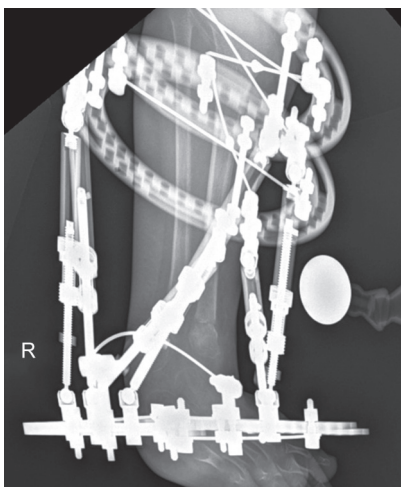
Antero-posterior radiograph showing initial correction post 1st stage supratalar biosseous osteotomy
